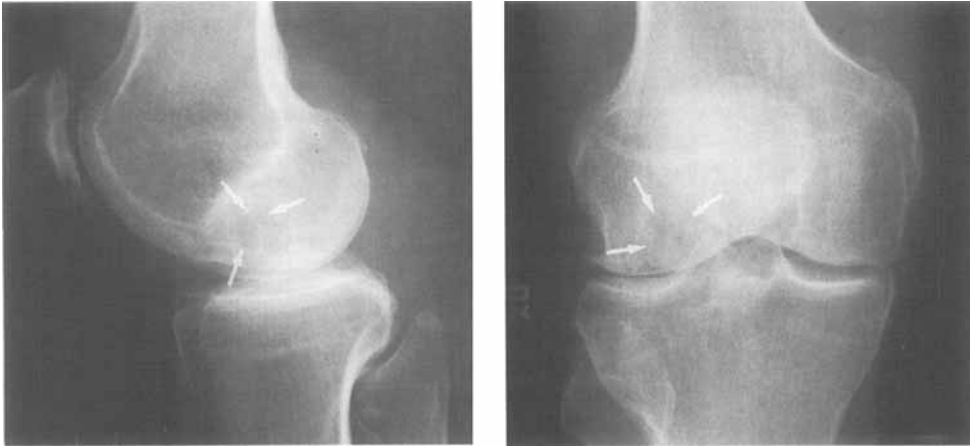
Case 1. Preoperative radiographs. Note joint space reduction and intraosseous cyst with sclerotic rim in the lateral femoral condyle (arrows).
